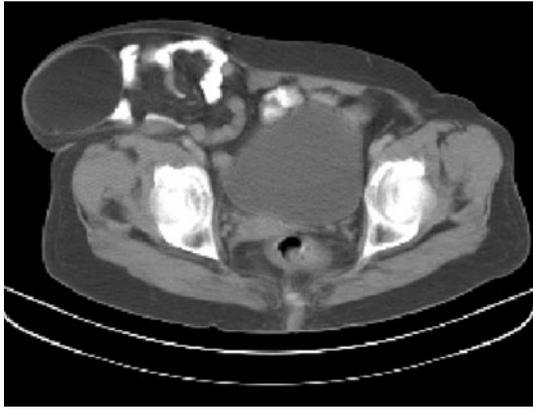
Computed tomography (CT) scan showing the ovarian dermoid in the hernial sac
